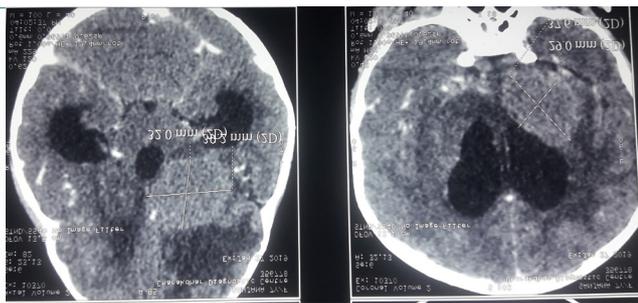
MRI brain showing mass lesion measuring 3 X 2.5 X 3 cm in left insular cortex with subtle post contrast enhancement and with non-communicating hydrocephalus
